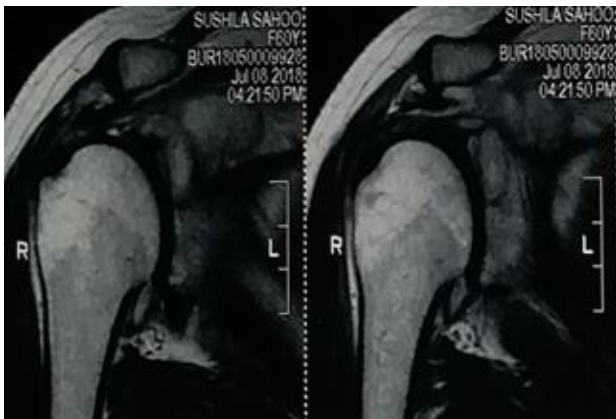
Pre debridement CT scan.
